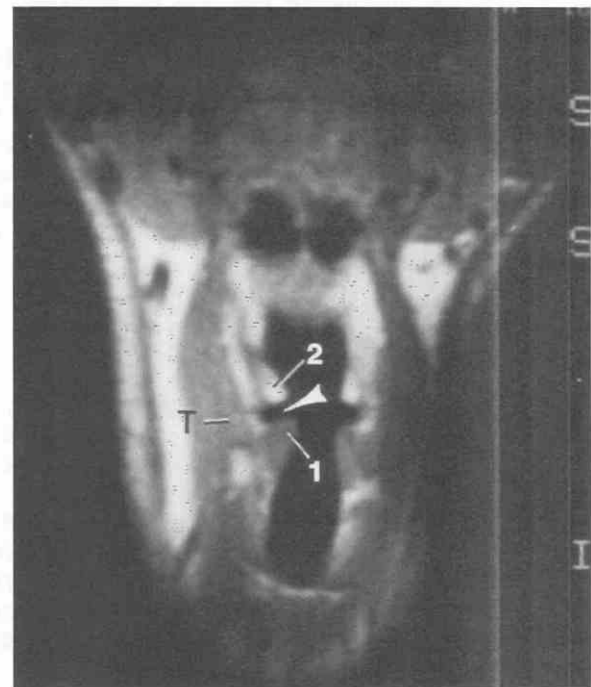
Coronal T1-weighted image. This slice would be perpendicular to the white line in Figure 18-2 at the level of 1 and 2. The thyroarytenoid muscle (1) makes up the bulk of the true cord. The paraglottic space at the level of the false cord (2) is filled predominantly with fat. The ventricle is the air-filled slit (arrowhead) between the two. T, thyroid cartilage. (From Curtin HD: *MR and CT of the larynx*. In Thrall JH [ed]: *Current Practice of Radiology*, 3rd ed. St. Louis, Mosby-Year Book, 1994.)
